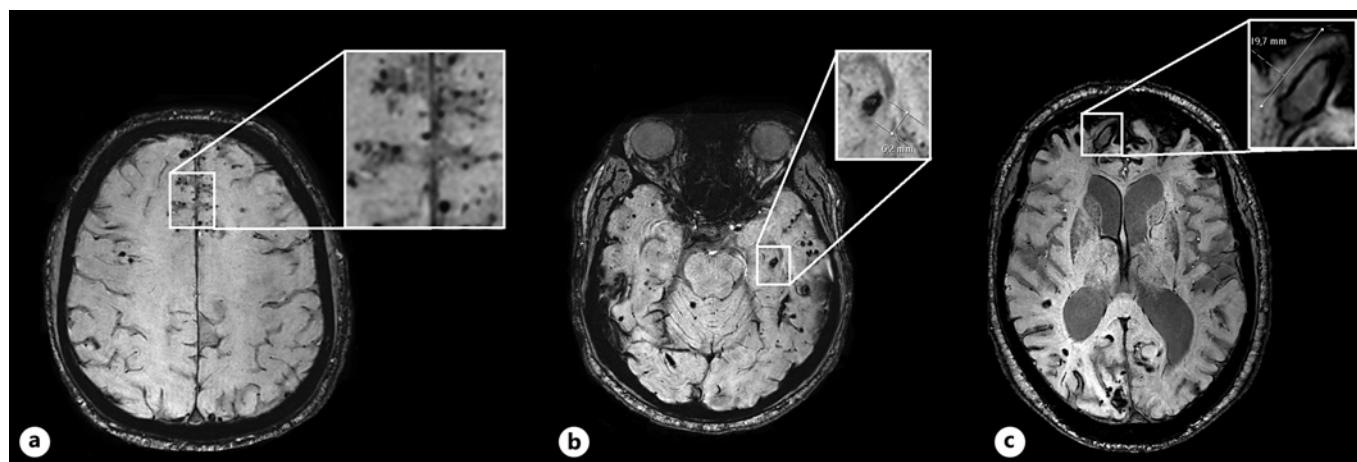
Example of a micro-, meso-, and macrobleed in CAA. 3T susceptibility-weighted images MRI at three levels in the brain of a participant with D-CAA showing examples of several microbleeds, typical round or ovoid small lesions with homogeneous aspect (a); a single mesobleed, with an irregular shape and a central cavity, the diameter is 6.2 mm (b); and a single macrobleed, with an irregular shape, diameter 19.7 mm (c).
